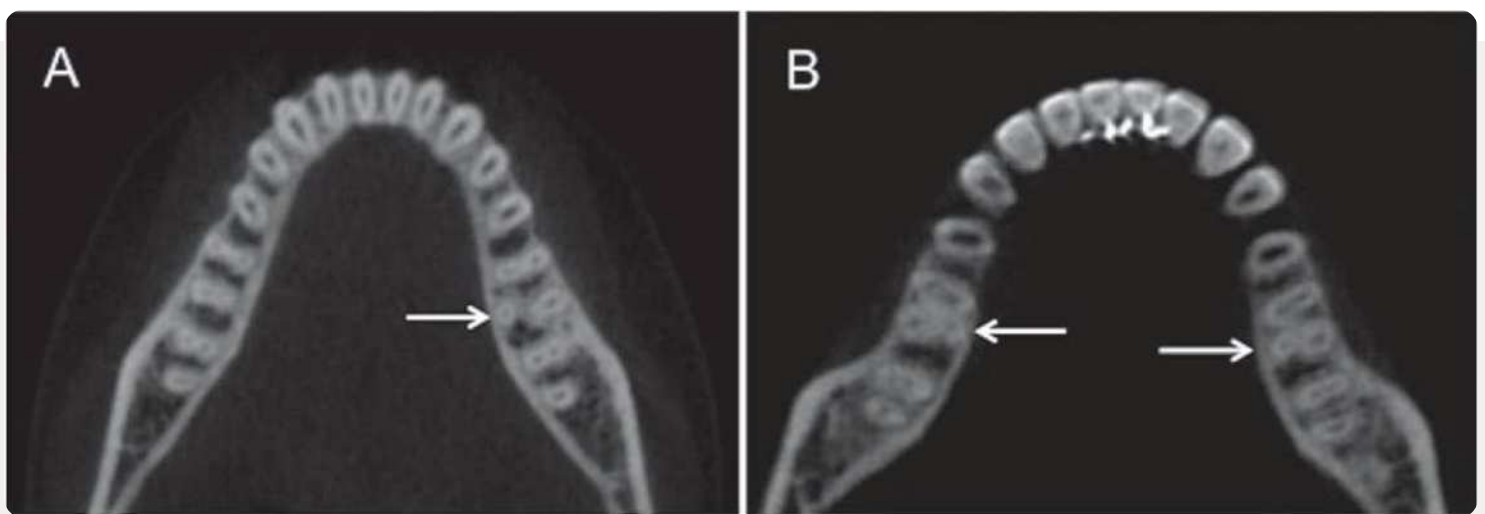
Cone-beam computed tomography images: (A) mandibular first molar with a distolingual root; (B) bilateral mandibular first molars with distolingual roots. From Rodrigues, C. T., Oliveira-Santos, C., Bernardineli, N., Duarte, M. A., Bramante, C. M., Minotti-Bonfante, P. G., & Ordinola-Zapata, R. (2016). Prevalence and morphometric analysis of three-rooted mandibular first molars in a Brazilian subpopulation. *Journal of applied oral science : revista FOB*, 24(5), 535–542. <https://doi.org/10.1590/1678-775720150511>
